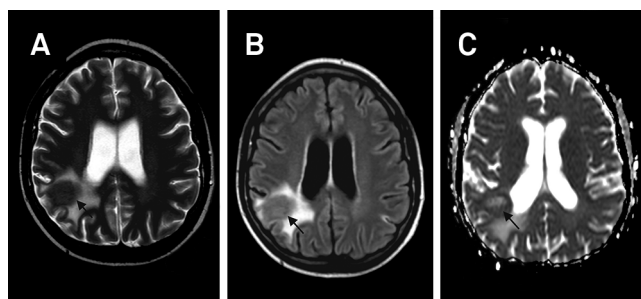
Follow up magnetic resonance imaging after 38 days of chemotherapy with methotrexate and cytosine arabinoside shows significant reduction of the tumor and mass effect on (A) T2 weighted image and (B) FLAIR; (C) ADC map shows areas of high signal suggesting the cellularity of the tumor was reduced over this period.
